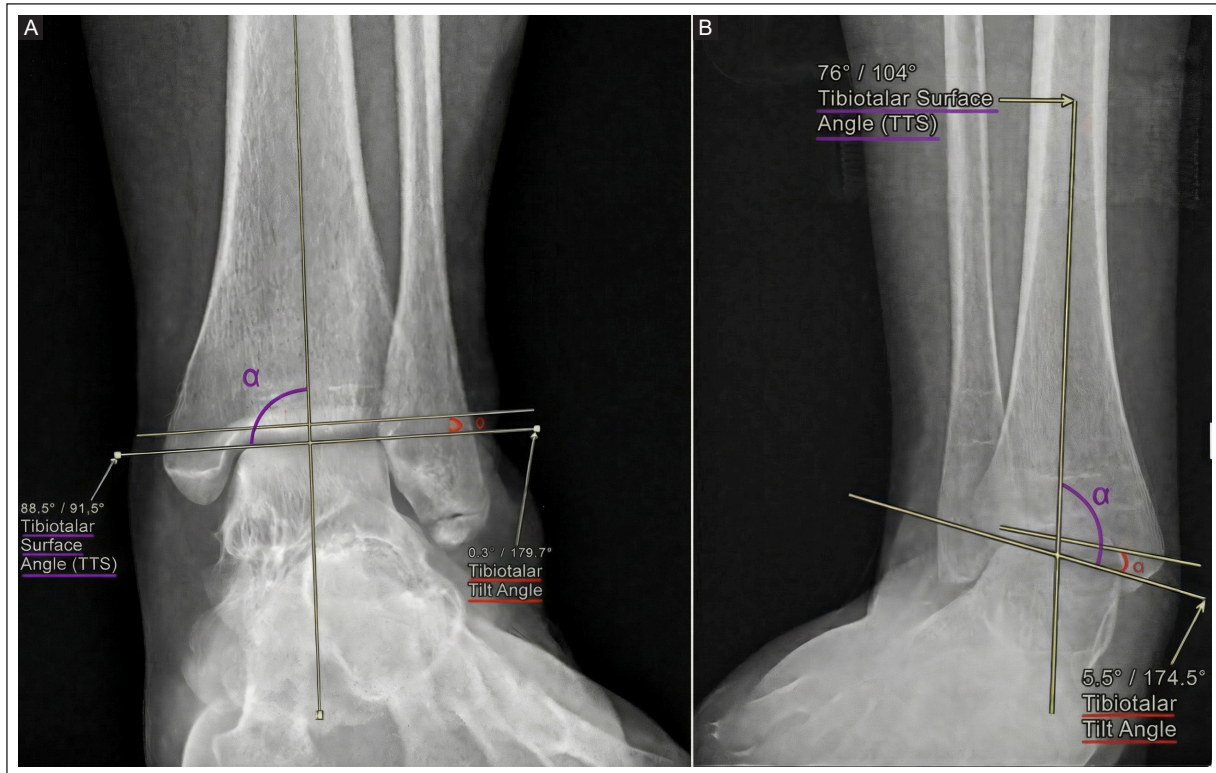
A: weight-bearing AP ankle radiograph with normal values. The tibiotalar surface angle is shown in purple, and the talar tilt (tibiotalar tilt angle) is shown in red. B: same angles and color coding on an AP radiograph with deformity.
